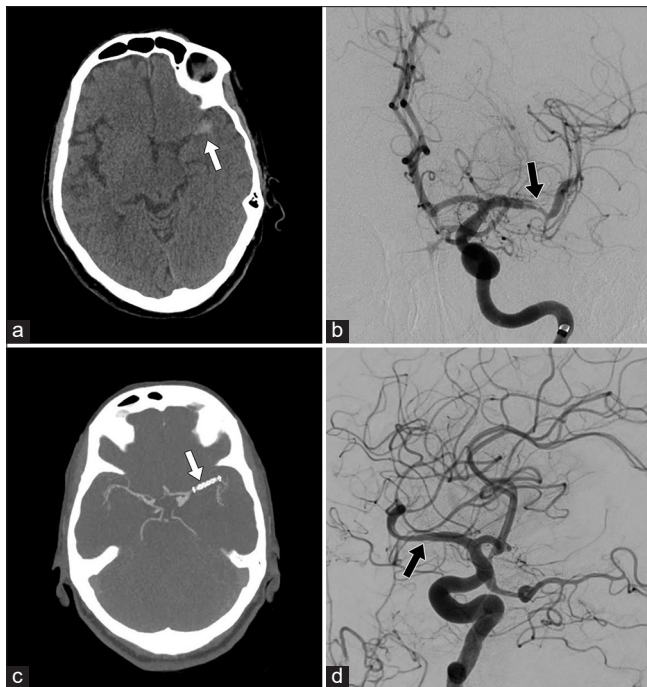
(a) Computed tomography (CT) of the head 7 days after mechanical thrombectomy demonstrating a new left inferior frontal intraparenchymal hemorrhage and a small left Sylvian fissure subarachnoid hemorrhage (white arrow); (b) Left internal carotid artery (ICA) cerebral angiogram performed 7 days after mechanical thrombectomy showing luminal narrowing of the left M1 segment (black arrow), compatible with a dissection flap; (c) Poststenting CT angiography of the head demonstrating stent placement (white arrow); (d) Left ICA cerebral angiogram confirms a patent left MCA (black arrow) with moderate in-stent stenosis (the angiogram was performed after treatment with intraarterial Integrelin).
